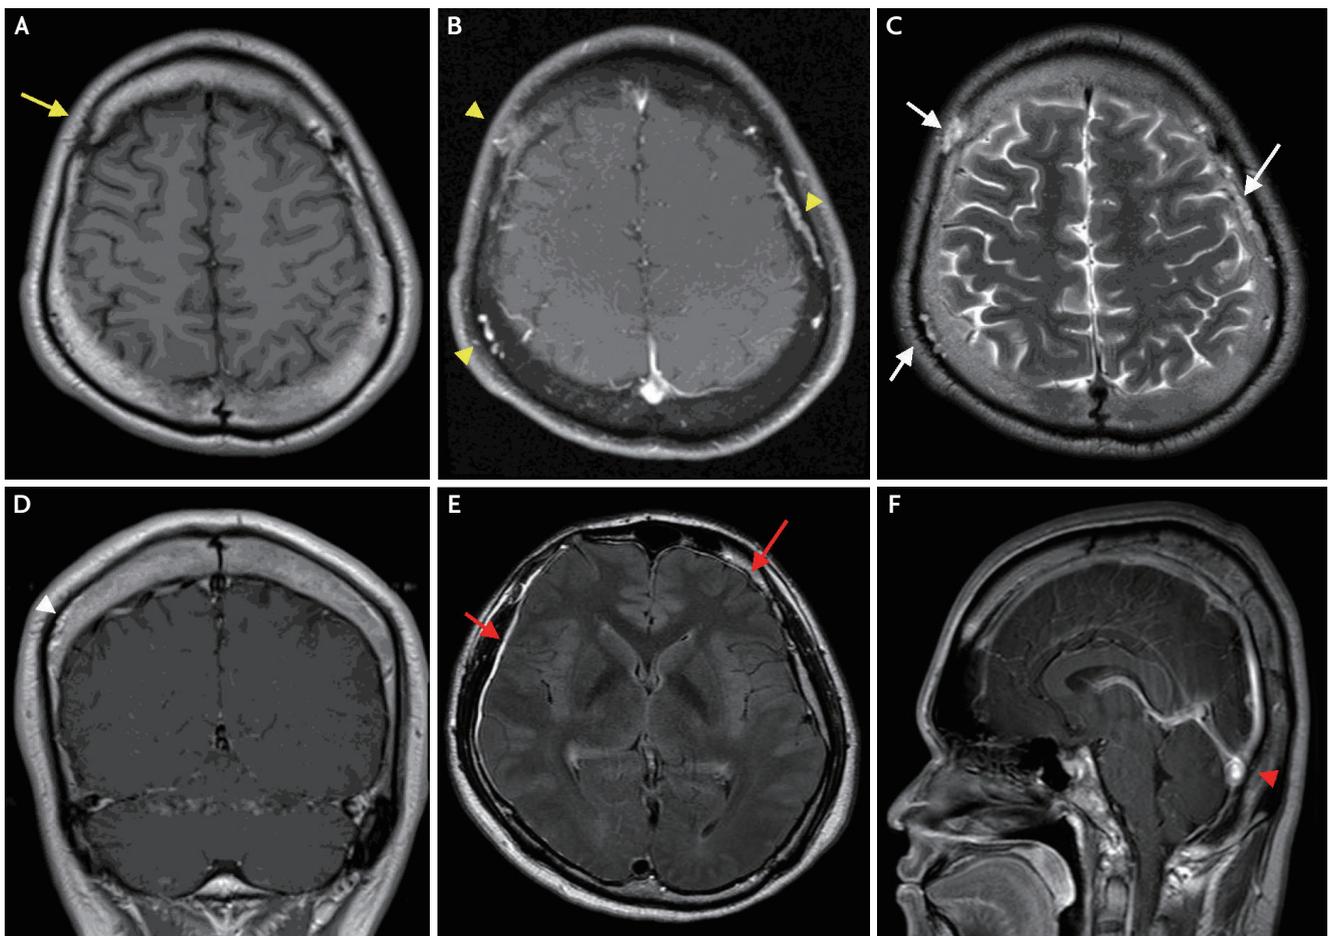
Brain MRI findings. The patient's brain MRI demonstrated right-sided lytic bony lesions and showed T2 hyperintense lesions of the right frontal and parietal and left temporal bones (white arrows) (C). These lesions showed heterogeneous enhancement on T1-weighted contrast-enhanced axial (yellow arrowheads) (B) and coronal images (white arrowhead) (D) compared to pre-contrast T1-weighted images (yellow arrow) (A). Brain MRI showed dural thickening of bilateral convexity with enhancement on fluid attenuated inversion recovery images, which was more severe on right side (red arrows) (E), and venous distension sign on T1-weighted contrast-enhanced imaging (red arrowhead) (F), both of which suggested intracranial hypotension. MRI; magnetic resonance imaging.
